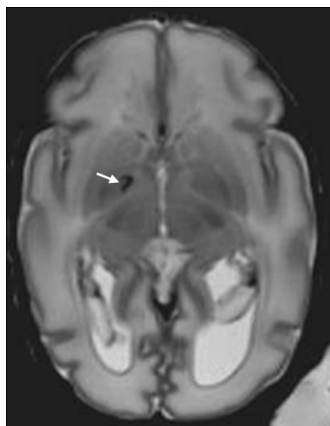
Transverse T₂-weighted MRI scan showing intraventricular haemorrhages and inhomogeneous signal intensity in the right lentiform nucleus compatible with haemorrhage (arrow).
